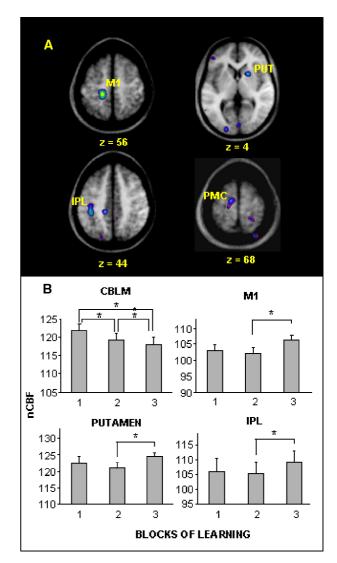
Panel A shows *t* statistic maps of significantly active regions in M1, the Putamen, PMC and IPL (Area 40) for the BLK3 vs. BLK2 contrast. PET data are co-registered with the average MRI of the 12 subjects and slice levels are given in the standardized space of Talairach and Tournoux. Images are thresholded at $t > \pm 2.5$ to allow visualization of regions of activation below the statistical threshold of $t > \pm 3.5$ that may be of interest. Panel B shows graphs of nCBF values extracted from VOIs in the cerebellum, M1, Putamen and IPL for BLK1-3 (For VOI locations, see Table 1). All regions showed significant differences between BLK2 and BLK3. The cerebellum showed significant differences between all three blocks of learning.
